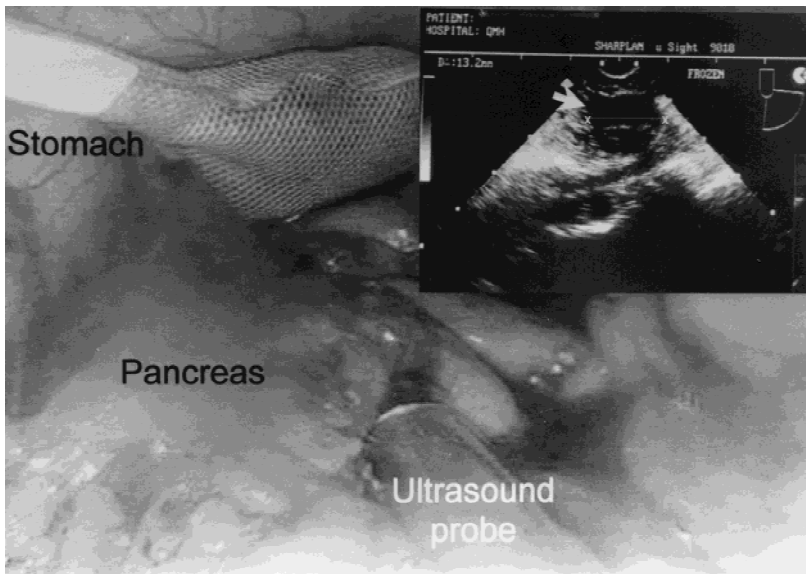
Laparoscopic ultrasonography (8-MHz) of the pancreatic tail demonstrates a 13-mm hypoechoic insulinoma (arrow).
